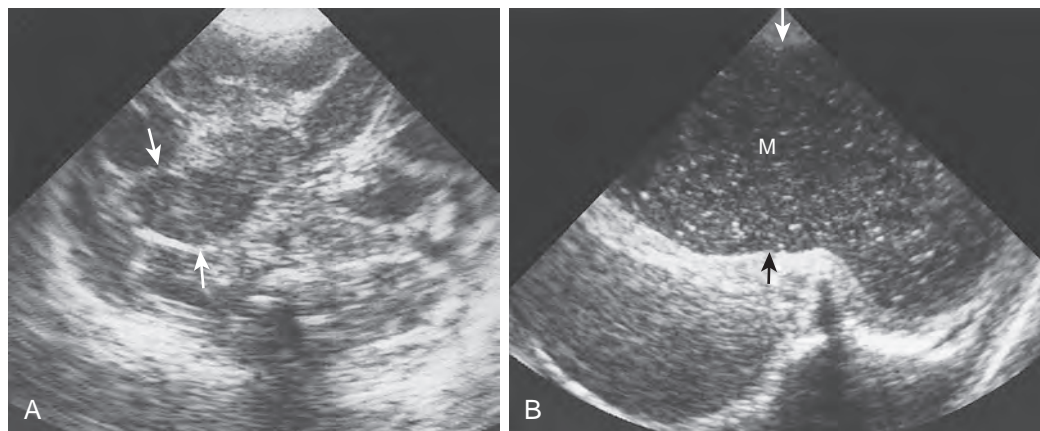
Ultrasound appearance of meconium ileus. A. Round loops of bowel (arrows) full of echogenic meconium are visualized on this transverse scan. B. Echogenic meconium (M) fills the dilated bowel loop (arrow).
